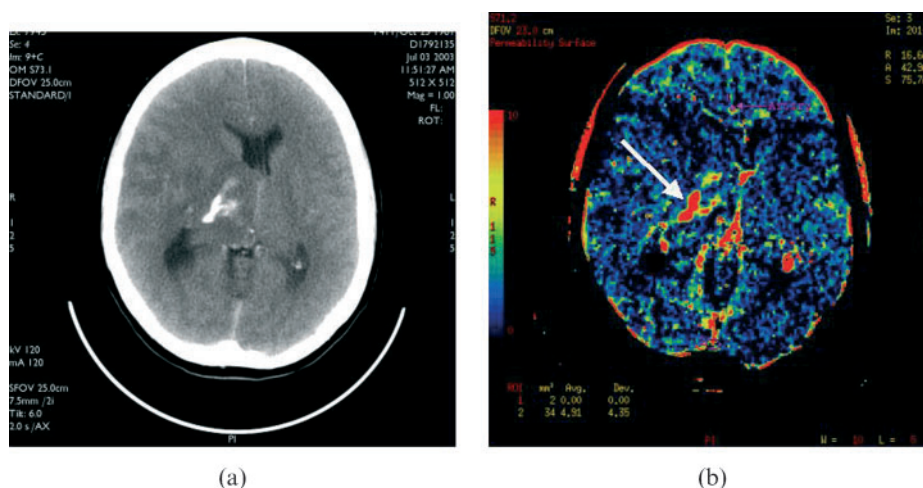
(a, b) Assessment of tumour vascularity. A 30-year-old male patient with a deep seated right hemispheric low-grade astrocytoma. The tumour had been under observation for 10 years and had been relatively static in appearance and the patient had also been clinically stable. The patient presented with increased seizures and headache, and tumour growth and/or upgrading was suspected. (a) Axial post-contrast cranial CT through the tumour in the right thalamus. There is central calcification and localized mass effect. (b) Image from the CT perfusion (CTP) study. Mean transit time (MTT), cerebral blood volume (CBV), cerebral blood flow (CBF) were normal. There is increased permeability in the central aspect of the tumour (arrow), indicating either a breakdown in the blood–brain barrier or increased vascularity. Either of these changes indicates that the tumour has upgraded. This was confirmed on subsequent biopsy.
